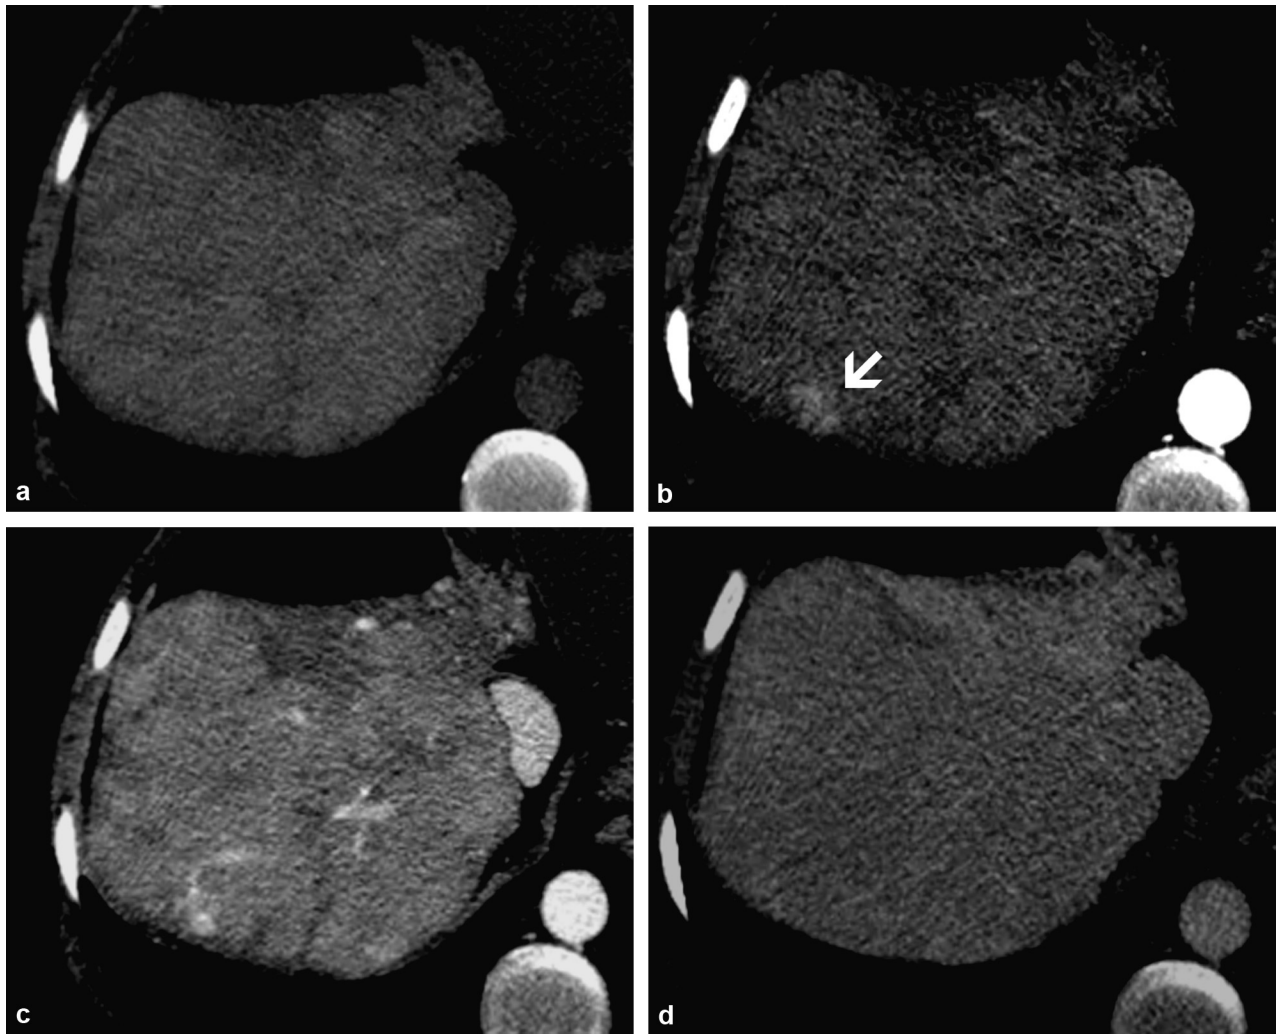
Arterioportal fistula. Monitoring examination for cirrhosis of exogenous origin. CT scan without (a) and after injection of an iodinated contrast agent in the arterial (b), portal (c) and late (d) phases: small peripheral arterioportal fistula (arrow) spontaneously isodense (a), responsible for parenchymal enhancement from the arterial phase, and which became homogeneous in the portal and late phases.
